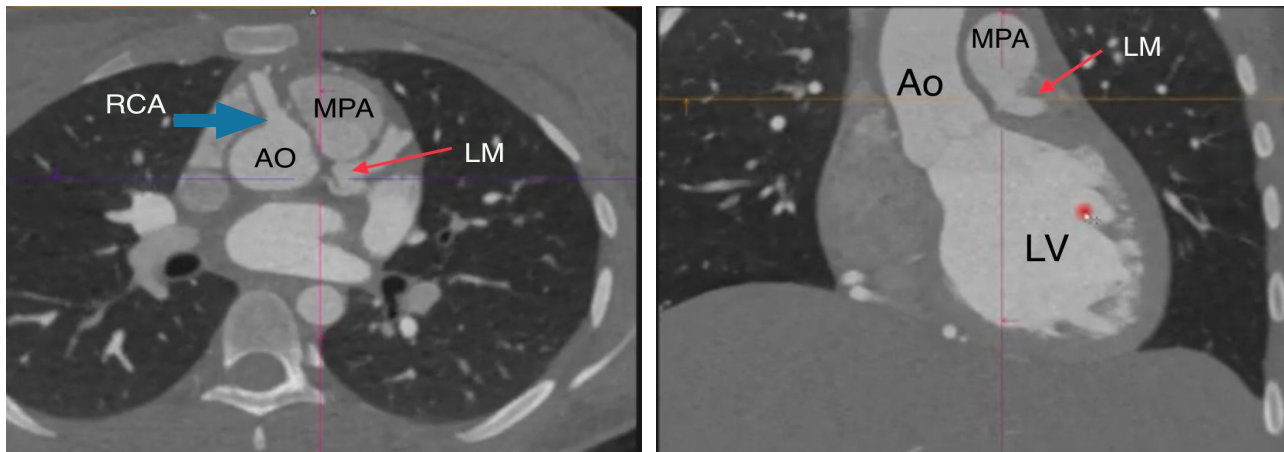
Coronary computed tomography: two-dimensional views of the proximal right coronary artery from the aorta (thick blue arrow) and anomalous left main coronary artery flowing into the pulmonary artery (thin red arrow). LM: left main coronary artery, AO: aorta, LV: left ventricle, MPA: main pulmonary artery, RCA: right coronary artery
